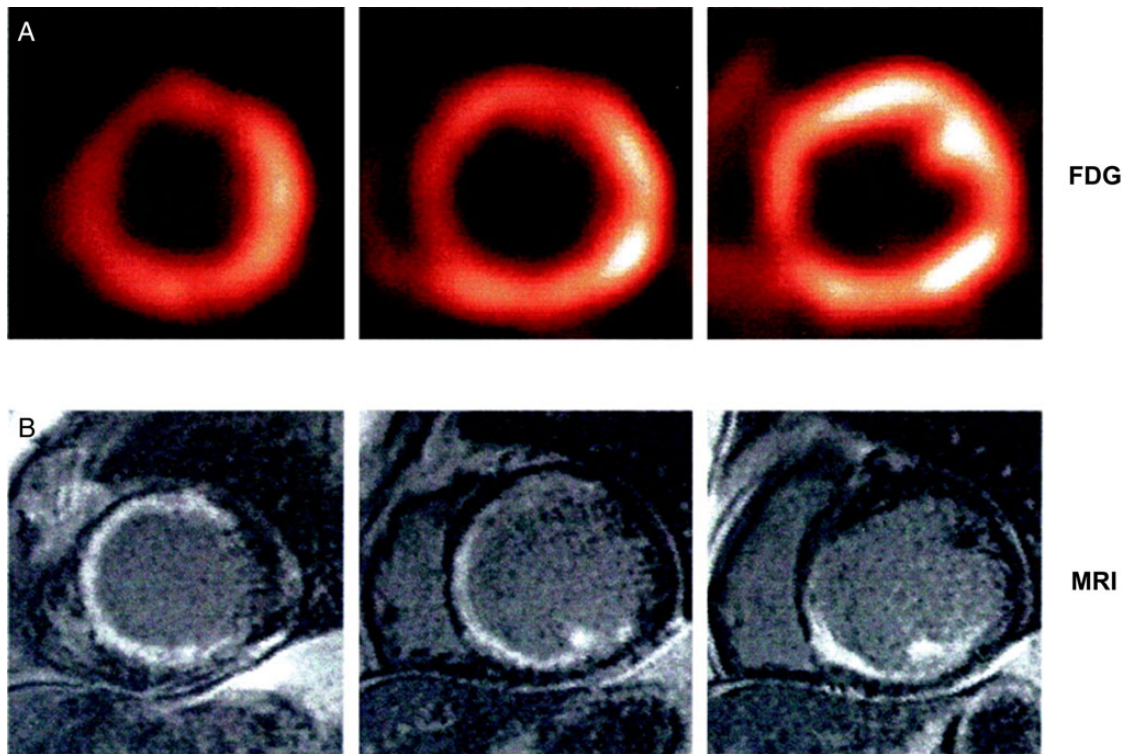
(A) Top panel with short-axis view (apical, mid-ventricular, and basal) of a fluorodeoxyglucose positron emission tomography viability study in a patient with old infarction. (B) Bottom panel with corresponding images of gadolinium-delayed enhancement magnetic resonance imaging signifying hyperenhancement of the subendocardial myocardial infarction. As can be seen, in the area of reduced fluorodeoxyglucose uptake on positron emission tomography, there is delayed gadolinium enhancement on magnetic resonance imaging. Owing the higher spatial resolution of magnetic resonance imaging, there is a distinction between widely transmural, subendocardial, and papillary defects can be performed. (With kind permission from reference: Klein et al.⁴⁰).
